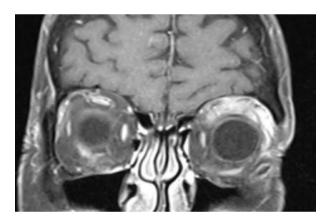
MRI of the orbit showing heterogenous enhancing soft tissue mass in left antero-superior orbit.
